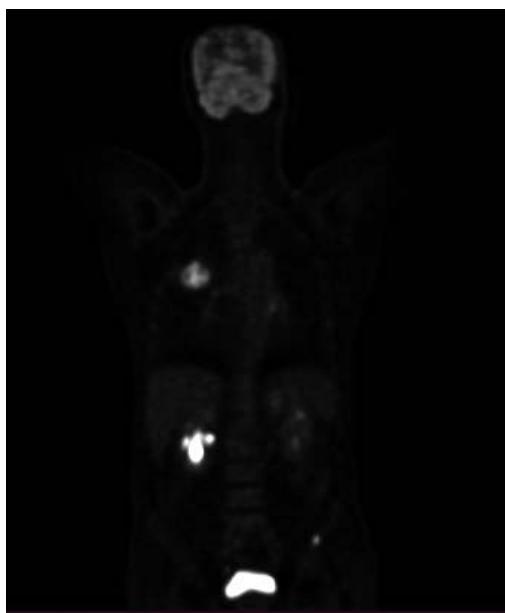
MIP appearance on the FDGPET/CT, highlighting the area of increased uptake on the left iliac bone.
